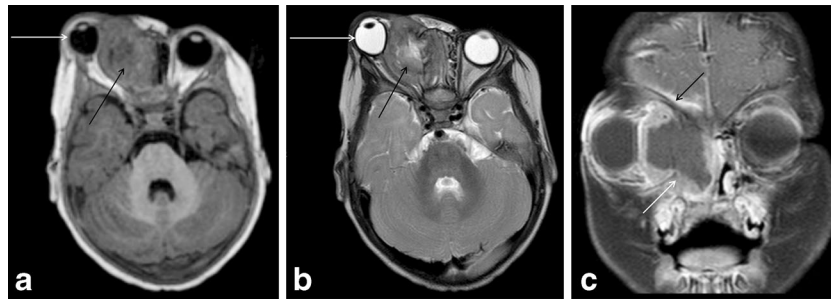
Brain MRI in a 1-year-old girl at presentation. Axial T1-W (a) and T2-W (b) images reveal a heterogeneous, predominantly T1 isointense, T2 hypointense medial orbital mass (*black arrow*) displacing the right
